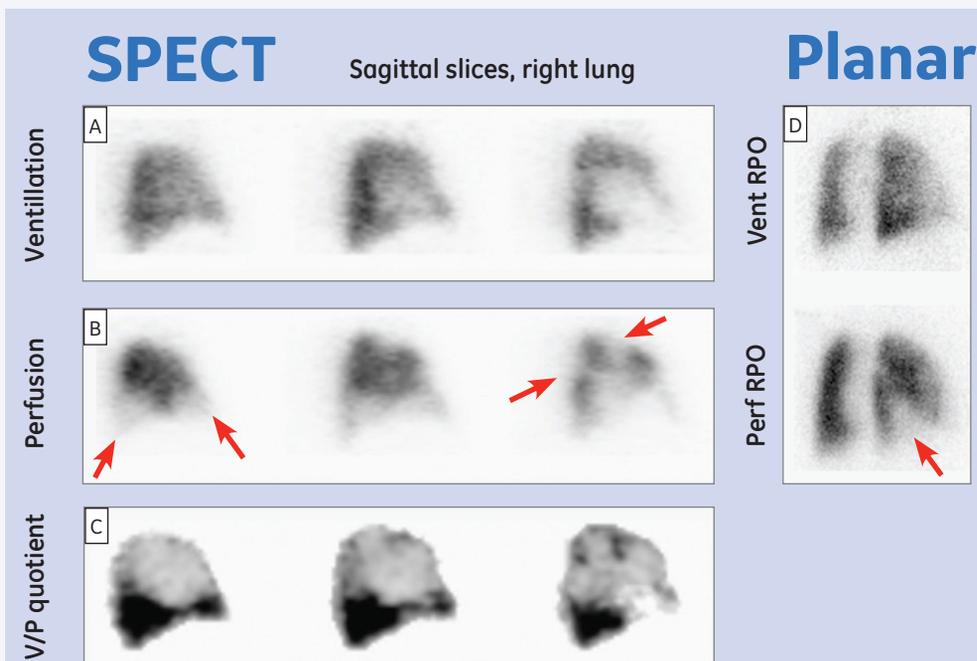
Patient with massive PE treated with thrombolysis; control images acquired the next day. On planar images only one perfusion defect is seen (D, arrow). On SPECT images (sagittal slices, right lung) segmental perfusion defects are still present in whole lower lobe as well as sub-segmental defects in upper lobe (B, arrows).
